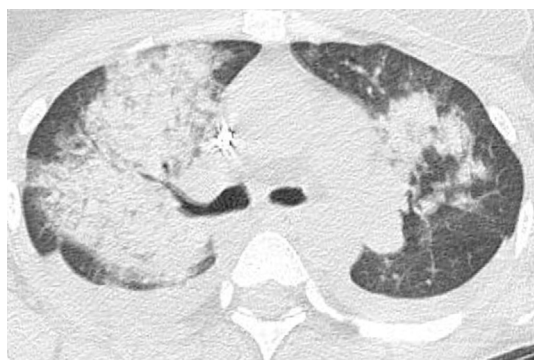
CT on the 8th day after admission showed diffusely distributed ground-glass opacities and severe alveolar hemorrhaging in both lung fields.
